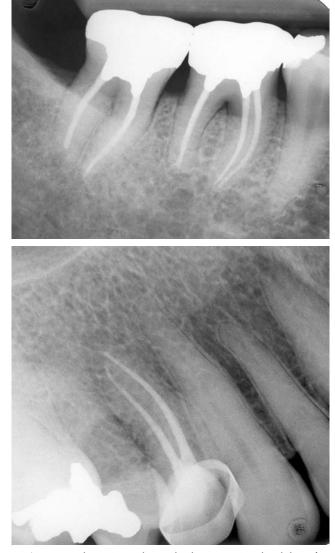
Post-obturation radiographs demonstrating the ability of rotary NiTi instrumentation to maintain canal curvatures.
